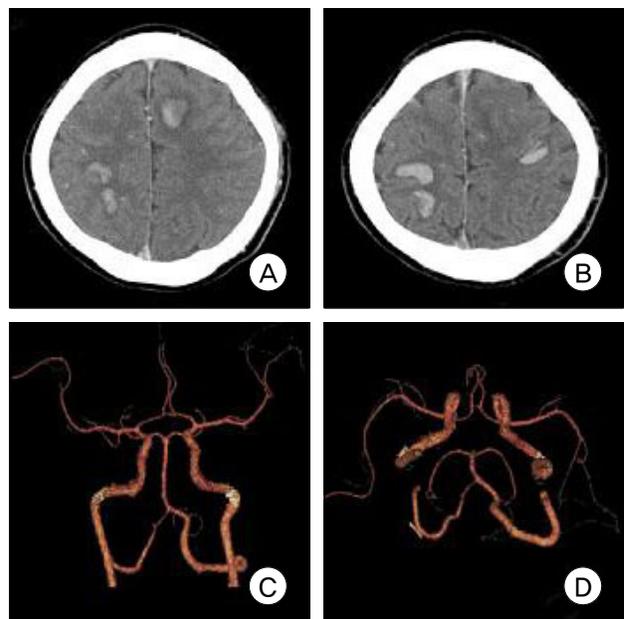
On follow-up brain CT scans, there are new onset foci and a slight increase of hemorrhage (A, B). CT angiography does not show any remarkable findings of major cerebral vessels (C, D).
